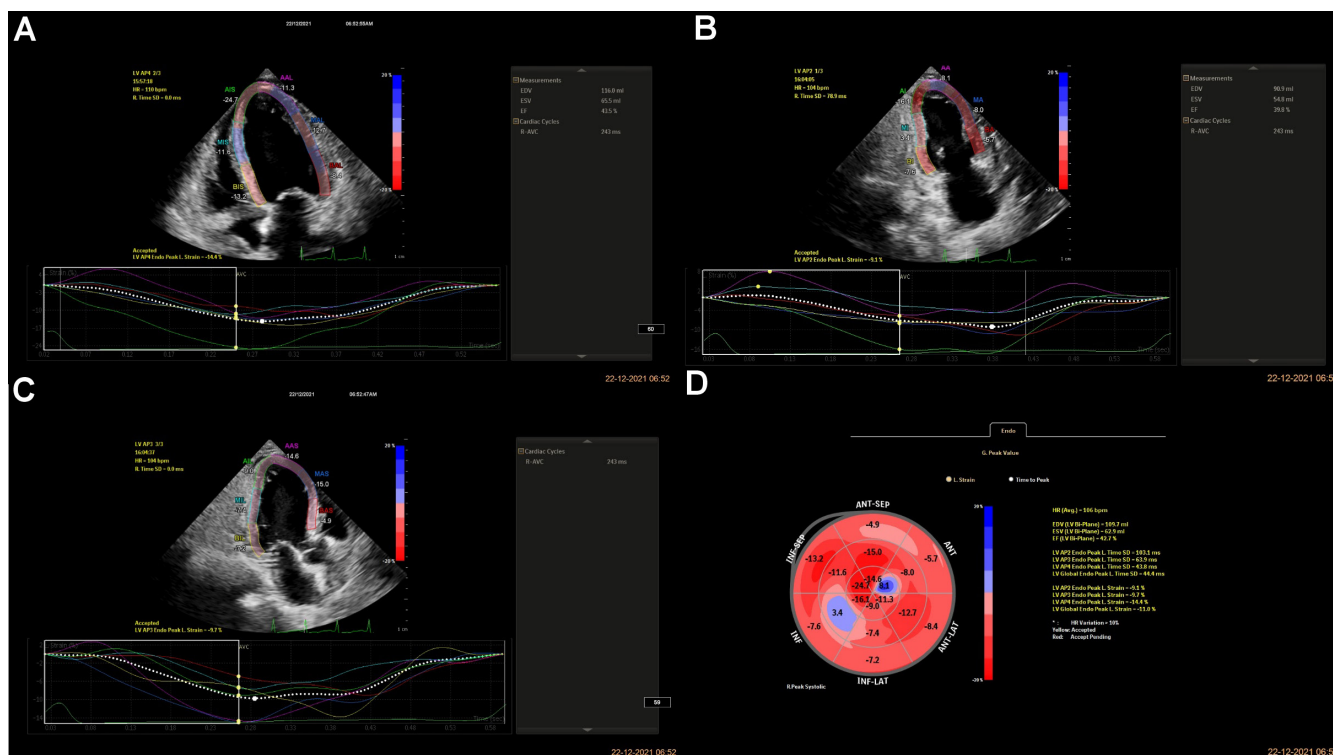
A – left ventricular apical four-chamber view (LVAP4); B – left ventricular apical two-chamber view (LVAP2); C – left ventricular apical three-chamber view (LVAP3); D – bull's eye view
